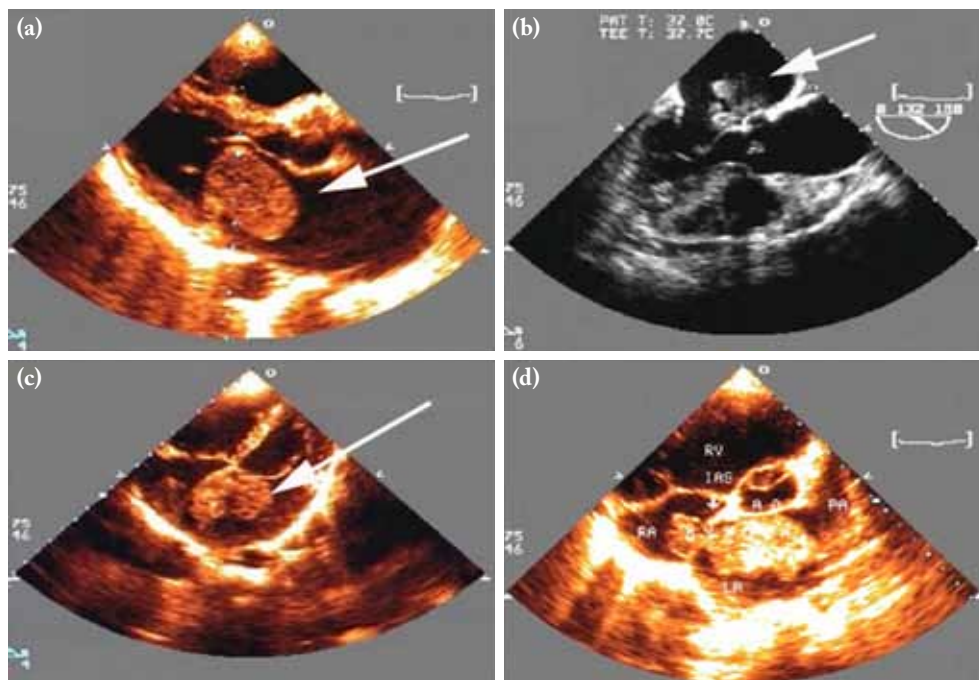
Transthoracic and transesophageal echocardiography images showing (a) a typical left atrial myxoma attached to the fossa ovalis of interatrial septum (arrow); (b) a multi-headed left atrial myxoma attached to the fossa ovalis of interatrial septum (arrow); (c) a left atrial myxoma attached to the interatrial septum and mitral valve-mimicking vegetation (arrow); and (d) a dumbbell-shaped myxoma, primarily in left atrium.
